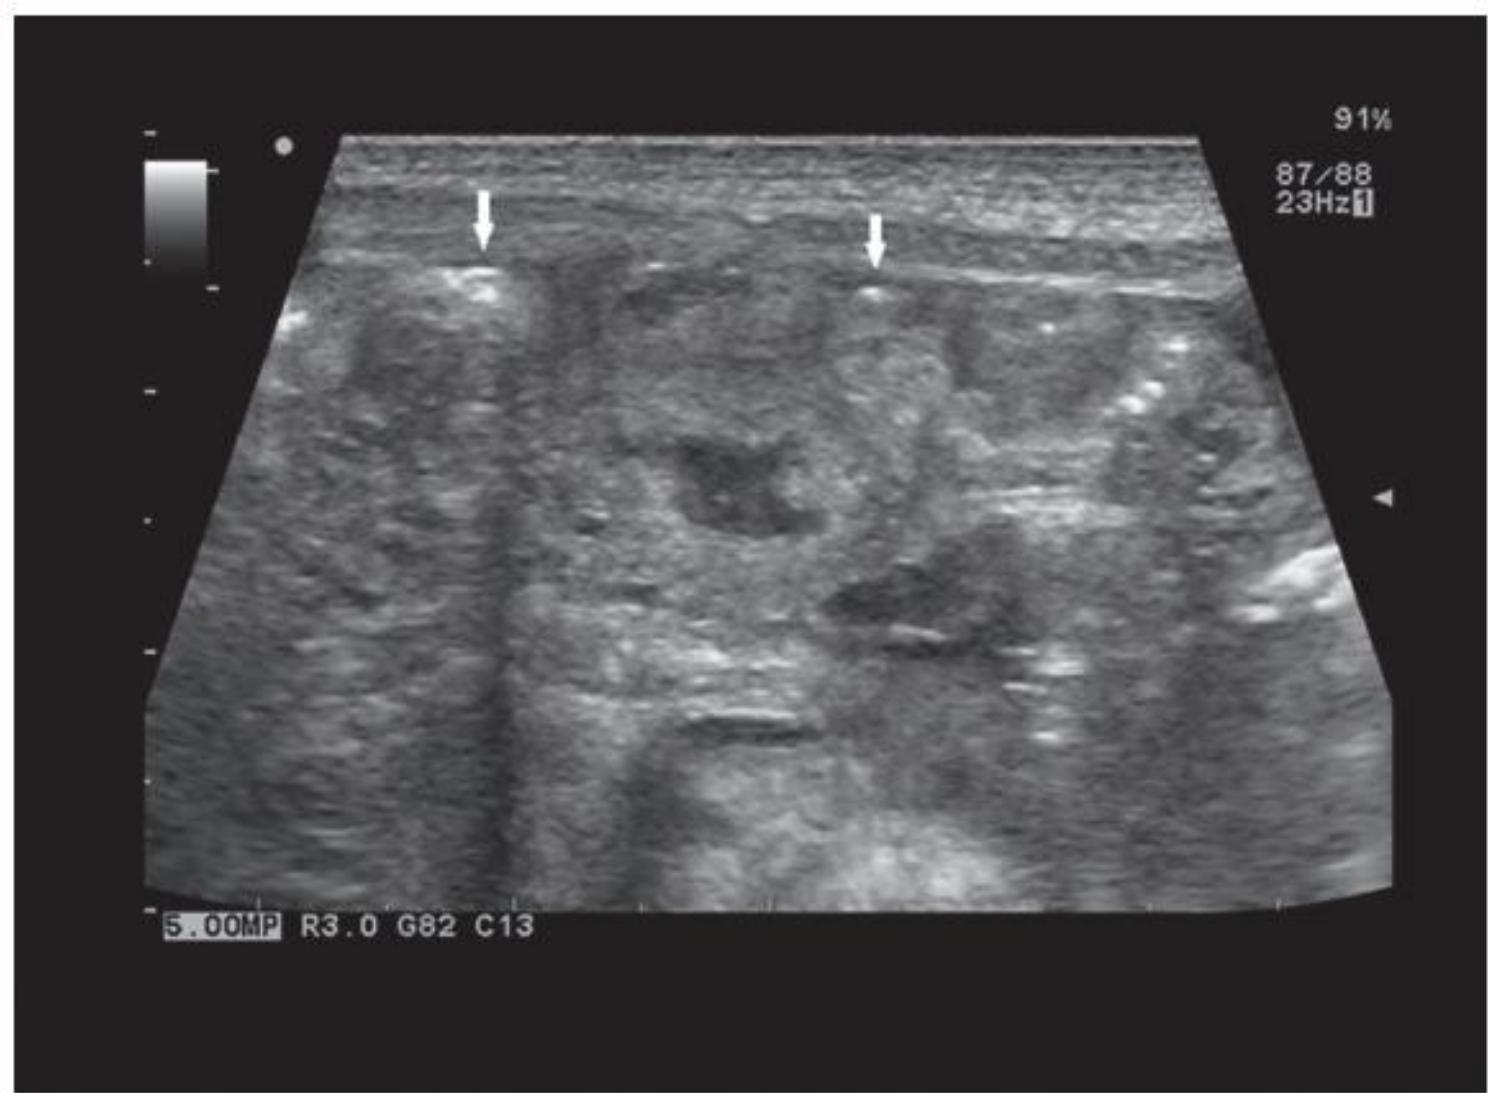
Ultrasound image of tiny intraperitoneal calcifications (arrows).
